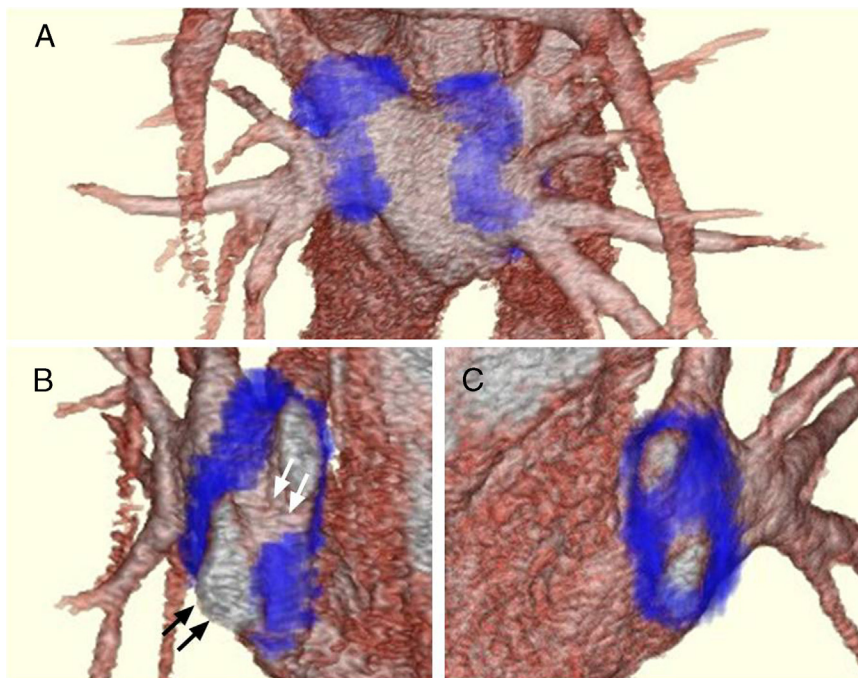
The overlaid images of 3-dimensional reconstructed delayed-enhancement magnetic resonance imaging and magnetic resonance angiogram in A: posterior-anterior view, B: right lateral view, and C: left cranial view. The site of delayed-enhancement is shown as the blue area. Panel A shows the lesion set at the posterior wall of the left atrium, which is wide and antral. Panel B shows the lesion set around the right pulmonary veins (PVs), in which discontinuity of the scar exists at the bottom of the right inferior PV (black arrows) and right PV carina (white arrows). Panel C shows the lesion set around the left PVs, which is dense and completely encircling.
